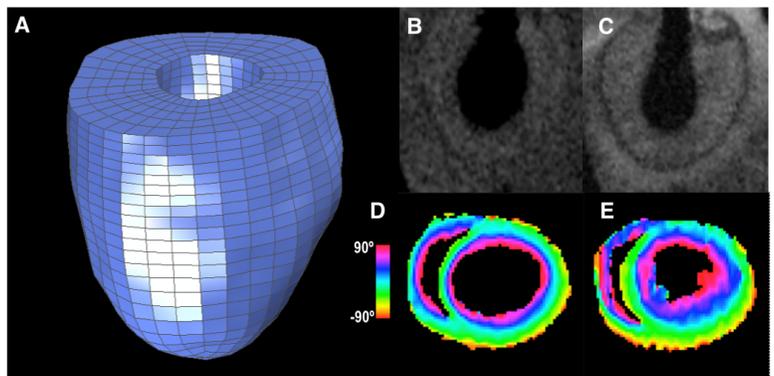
Representative converged patient-specific FE model (A), CINE magnitude images at ED (B) and ES (C), and DT-MRI fiber helix angle orientation maps at ES (D) and ED (E) obtained from the same left ventricle.
